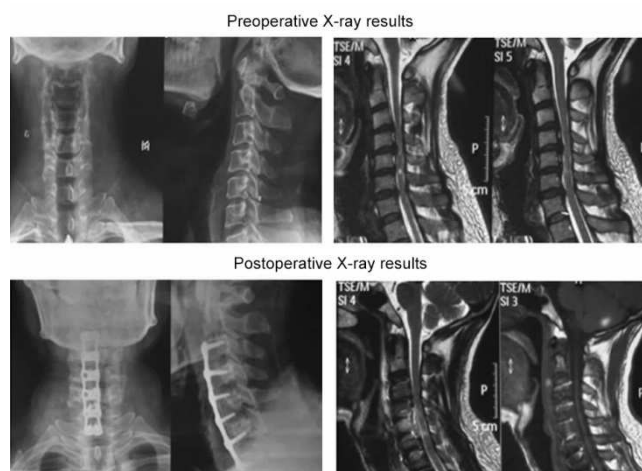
The representative PA & LAT X-ray results of patients preoperative and postoperative.
